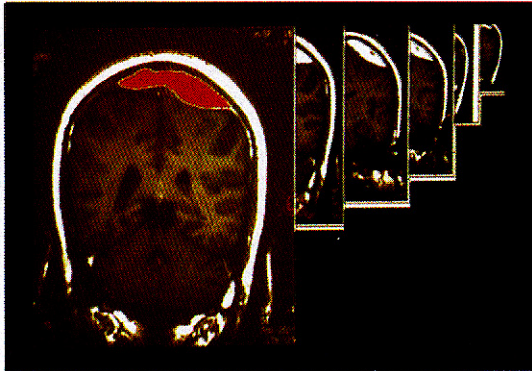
Quantification of the hematoma was performed with coronal MRI slices using computed software. The estimated volume of the hematoma was about 47cc.
